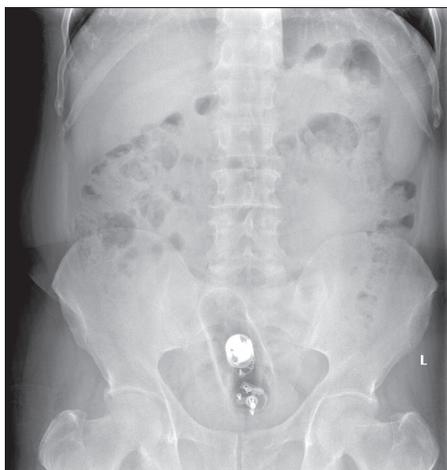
An abdominopelvic roentgenogram showed a vibrator
